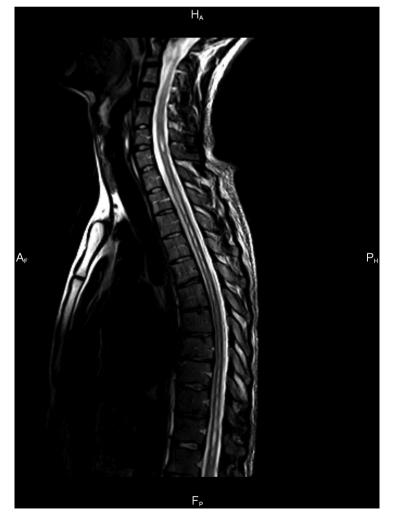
MRI of the cervical and thoracic spinal cord, sagittal plane, T2-weighted. Syrinx formation at the cervical and thoracic spinal cord 47
